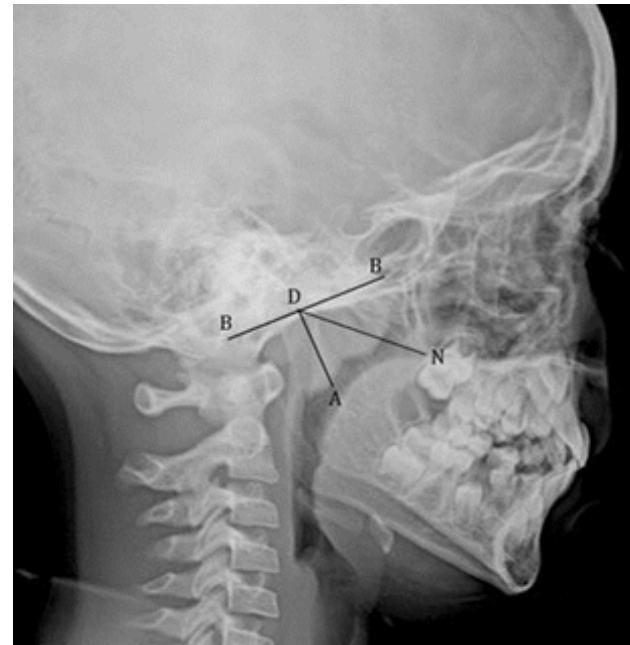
plain radiograph of nasopharynx lateral view (LNx) showing how adenoidal – nasopharyngeal ratio was calculated. BB: line drawn along straight part of anterior margin of basiocciput, AD:adenoid depth (perpendicular line from BB to most convex part of adenoid pad), ND : Nasopharyngeal depth (line between spheno-occipital synchondrosis to posterior edge of hard palate), ANR calculated by dividing AD with ND
